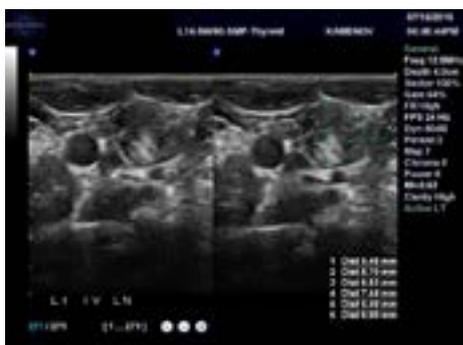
Ultrasound appearance of the suspected metastatic lymph nodes on which FNA and thyroglobulin wash-out was performed.
